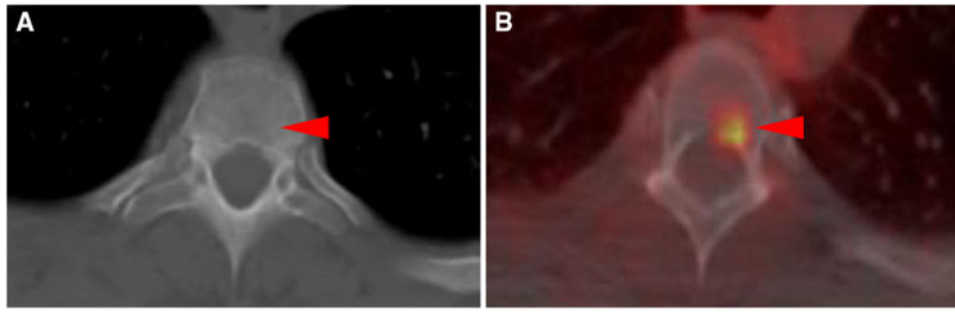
T3 vertebral body bone lesion from patient #5 which was occult on contrast-enhanced CT of the chest (a), but demonstrated moderate radiotracer uptake (SUV_{max} 2.6) when imaged with ^{18}F -DCFPyL PET/CT (b) (*arrowheads*)
